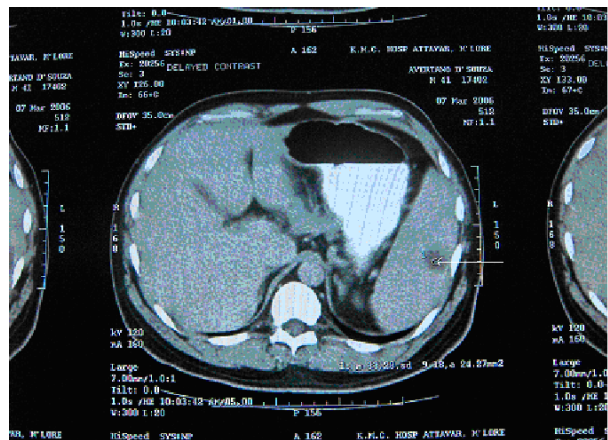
Repeat CT scan of the abdomen (after a month) showing a significant reduction in the size of the spleen (from 17 cm to 13 cm) and resolution of infarcts.
